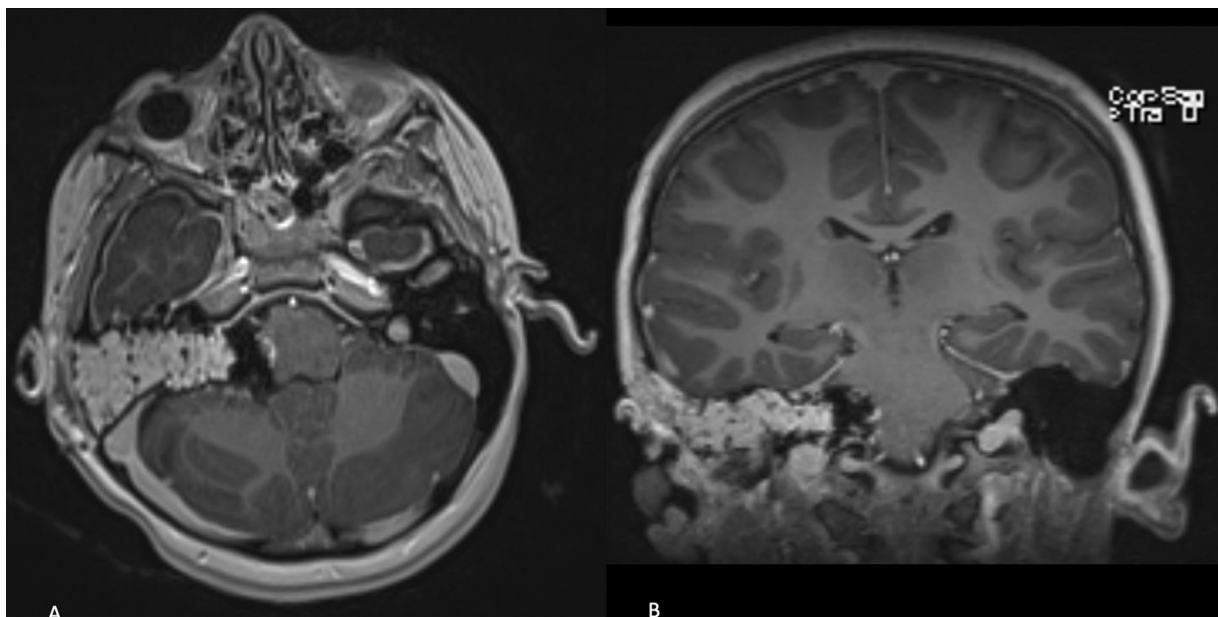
Postoperative MRI showing gross total resection through a translabyrinthine approach with fat graft. (A) Axial T1 with contrast. (B) Coronal T1 with contrast.
